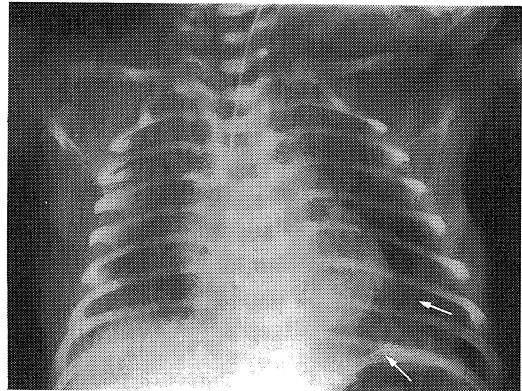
Chest X-ray 16 hours after birth. Bulla was detected in the left lung (arrow).
